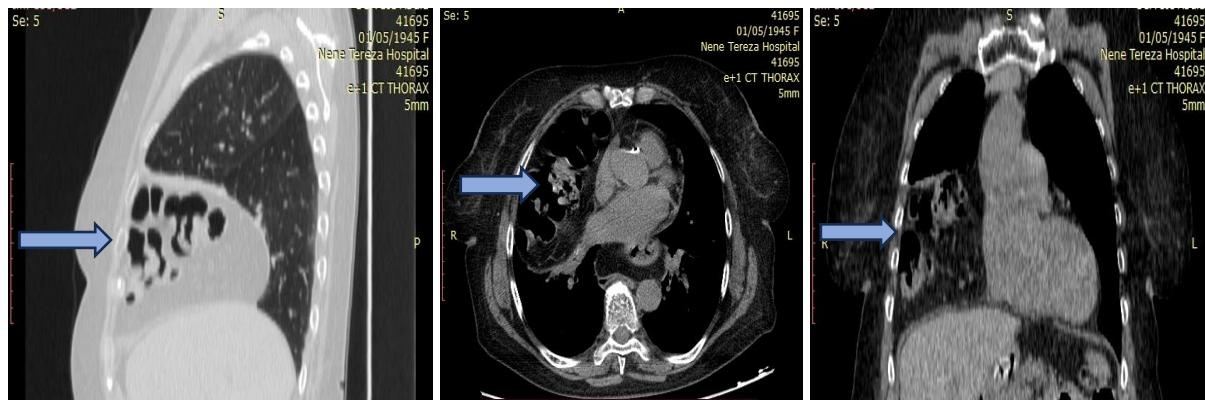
The CT scan revealed that the trachea and main bronchi were normal. It also identified a right-sided diaphragmatic hernia involving the ascending colon, without signs of incarceration.
